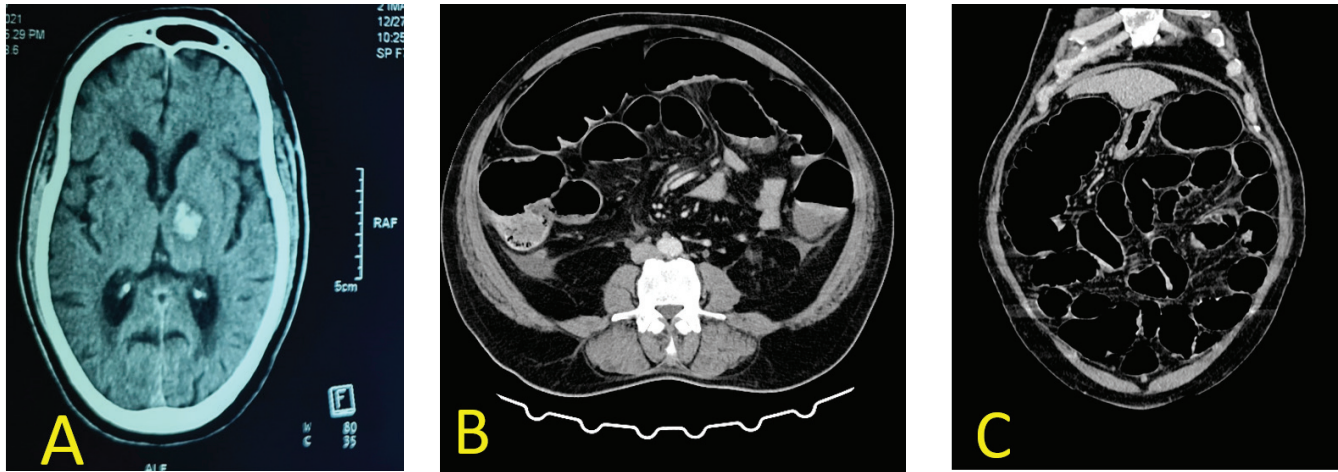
Showing a 55 year old man with acute colonic pseudo obstruction on day 5 of thalamic haemorrhage A) Non-contrast enhanced CT scan of brain axial section showing left thalamic haemorrhage B) Axial contrast enhanced CT image of the abdomen showing dilated bowel loops with air-fluid levels and ascites C) Coronal reformatted contrast enhanced CT image of the abdomen showing multiple dilated bowel loops.
